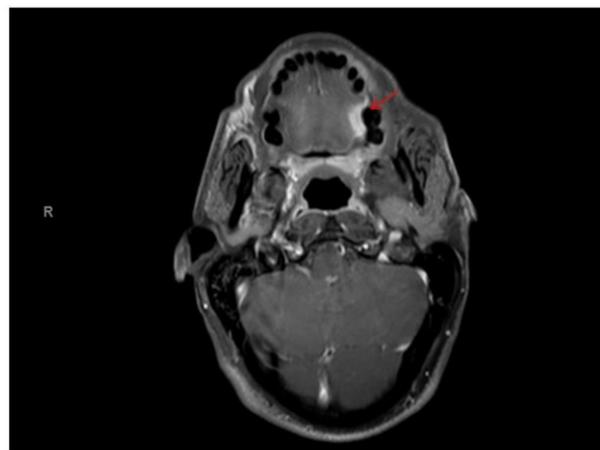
MRI of the Head and Neck area at the level of the tongue, pre contrast study showing a hyperintense irregular area at the left side of the tongue 2cm in maximum diameter (T2/T1 N0).
